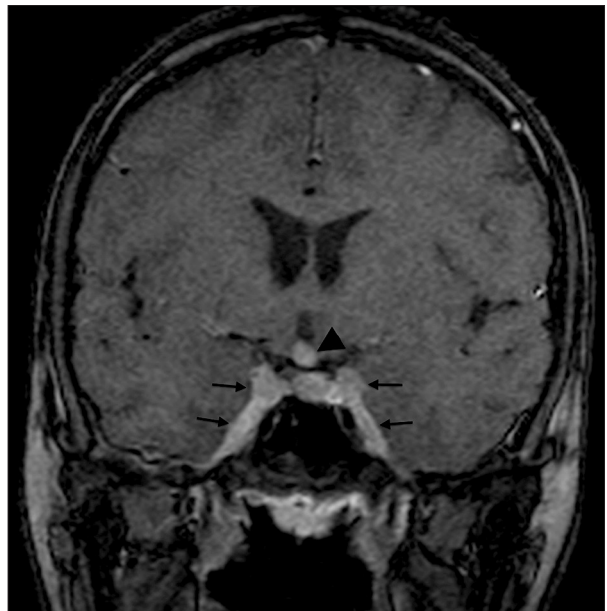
Axial MRI section with T1-weighted sequence with fat suppression after administration of paramagnetic contrast medium. There is high uptake of the contrast medium in the lesions in the cavernous sinus and Meckel's cave (arrows). High uptake is also observed in the lesion in the hypothalamus (arrowhead).
